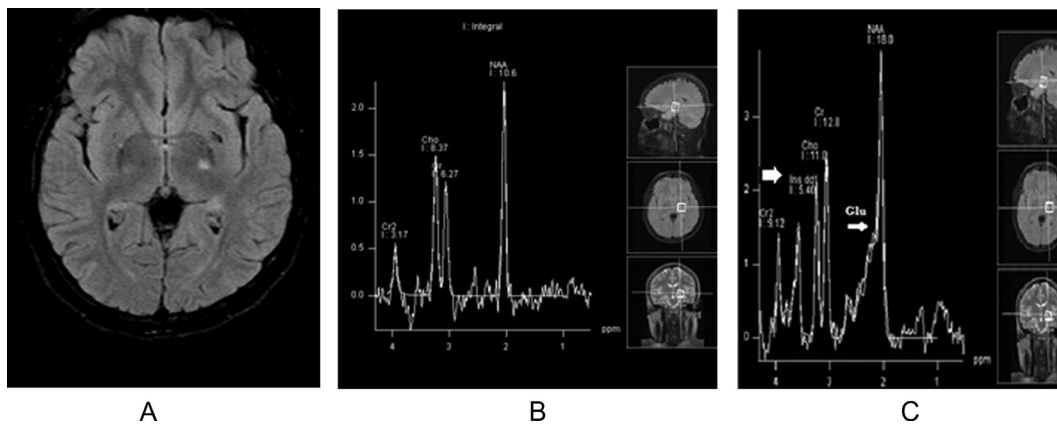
Female patient 24 years old with acute MS (A) Axial MRI brain T2 weighted FLAIR images showed left basal ganglia hyperintense lesion, (B) and (C) MRS at long and short TR showed: Elevated glutamate (thin white arrow) and myoinositol (thick white arrow), with elevated cho/Cr.
